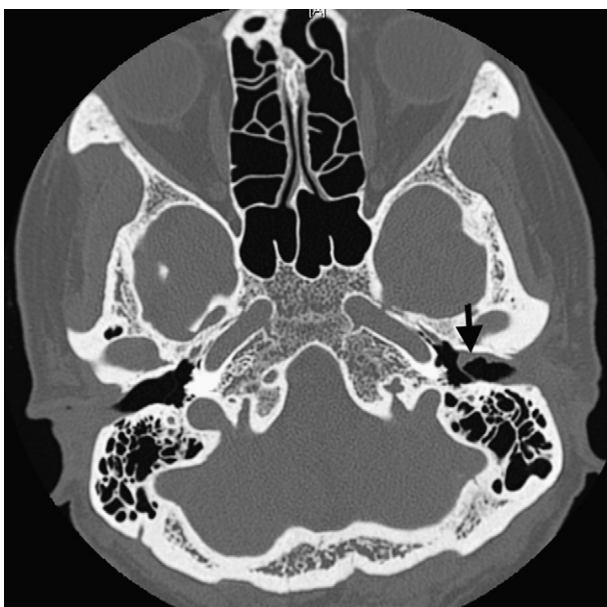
The computed tomography discloses increased soft tissue density (arrow) around left external auditory canal close to the tympanic membrane.
